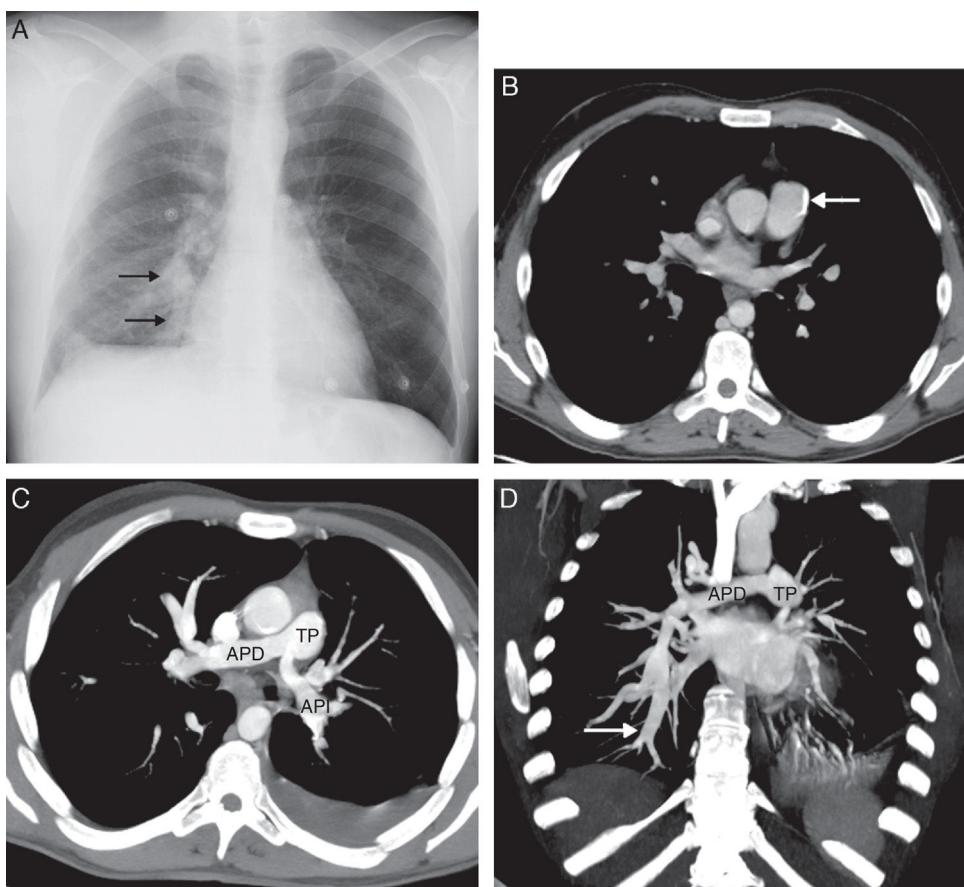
(A) Posteroanterior chest radiograph, showing increased caliber of arteries in the right lung base (arrows). Note the oligemia in the left lung compared to the right. (B) Axial image of chest CT, showing a calcified atheromatous plaque (arrow) in the wall of the pulmonary artery trunk. (C) Axial maximum intensity projection (MIP) reconstruction of chest CT, showing stenosis of the main pulmonary arteries, particularly in the left side (right main pulmonary artery [APD]; left main pulmonary artery [API]; pulmonary artery trunk [TP]). (D) Coronal MIP reconstruction of chest CT showing segmental artery in right lower lobe (arrow) of larger caliber than the APD (APD, TP).
